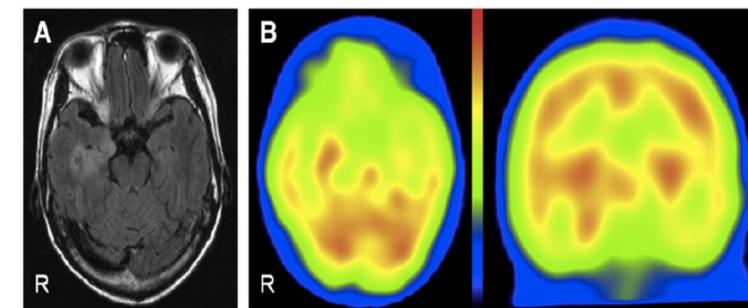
MRI and SPECT images showing right temporal and medial abnormalities in a patient who developed Fregoli syndrome after a cerebral haemorrhage (Sakurai et al., 2012).
